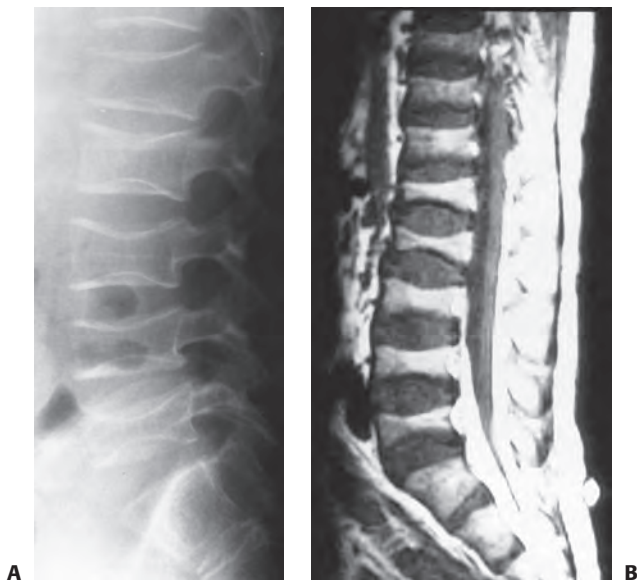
This 18-year-old boy with sclerosing cholangitis and a history of steroid use presented with several months of worsening low back pain. A: Lateral radiograph of his lumbar spine shows marked osteopenia, collapsed codfish vertebrae with sclerotic end plates and widened disc spaces and Schmorl nodes. B: This MRI shows flattened concave vertebrae that are smaller in most locations than the adjacent intervertebral discs. He was successfully treated with 3 months in a thoraco-lumbar-sacral-orthosis brace, followed by weaning from the brace and conditioning exercises.
